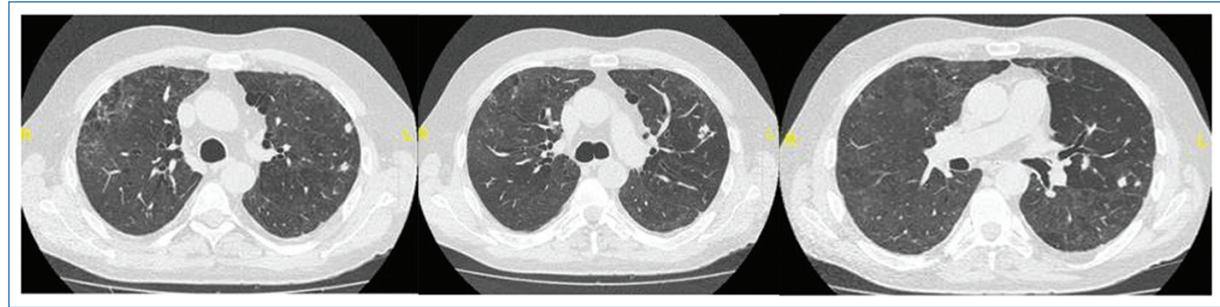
Pulmonary nodules in CT scan.
